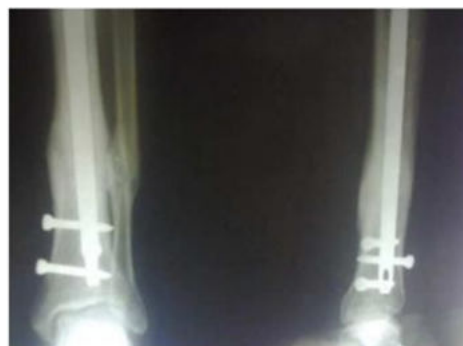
X-ray 12 months Post-Op, showing consolidated union.
